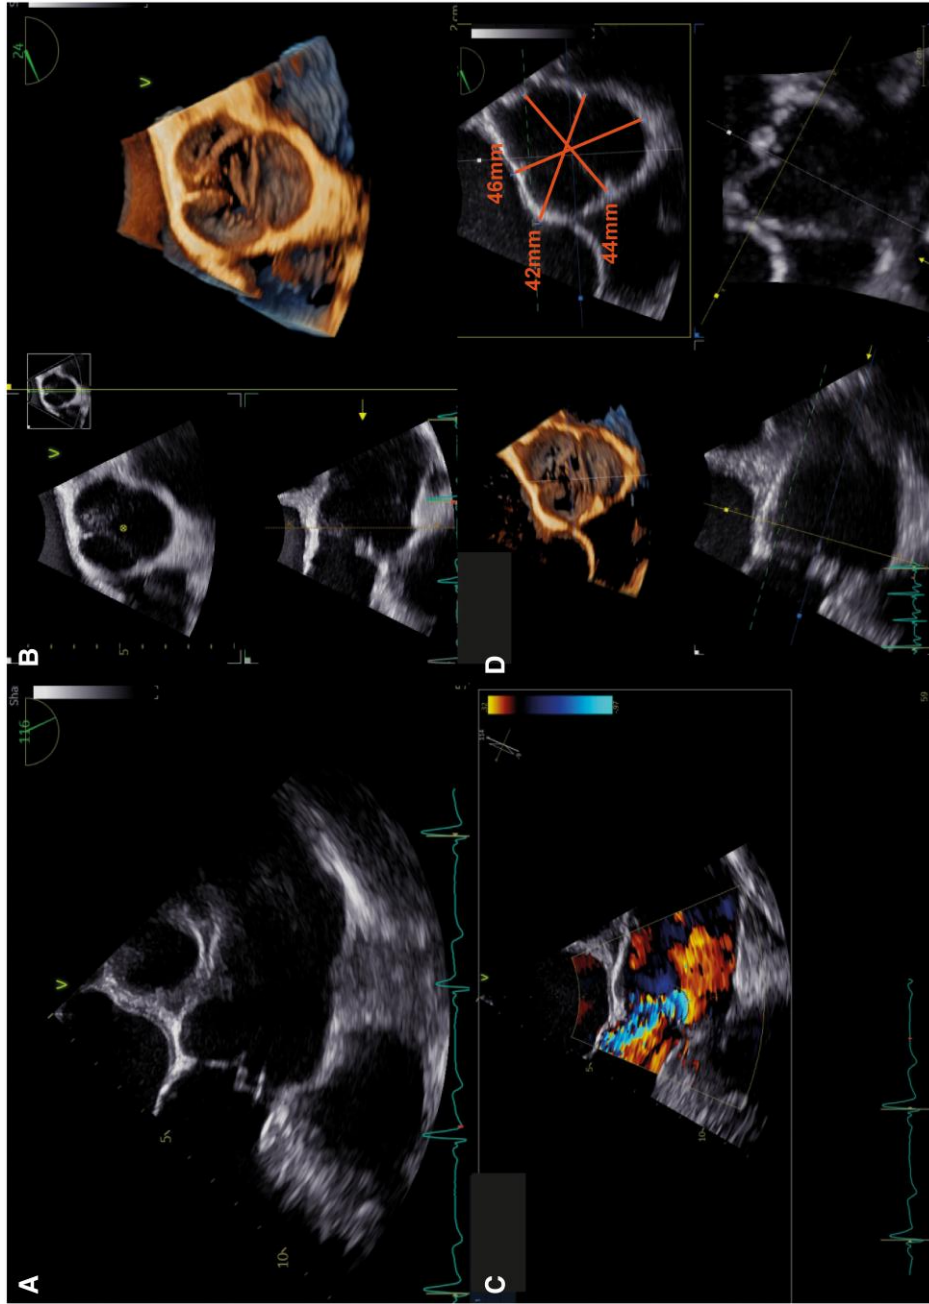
Primary aortic regurgitation in a 71-year-old man. Two- and 3-dimensional transoesophageal echocardiography revealed a 'transverse fold' in the right coronary cusp (panels A and B), suggestive of cusp prolapse (more frequently observed in men). Colour Doppler imaging demonstrated a markedly eccentric, severe regurgitant jet (panel C). By 3D transoesophageal imaging, the aortic root appeared dilated (panel D).
